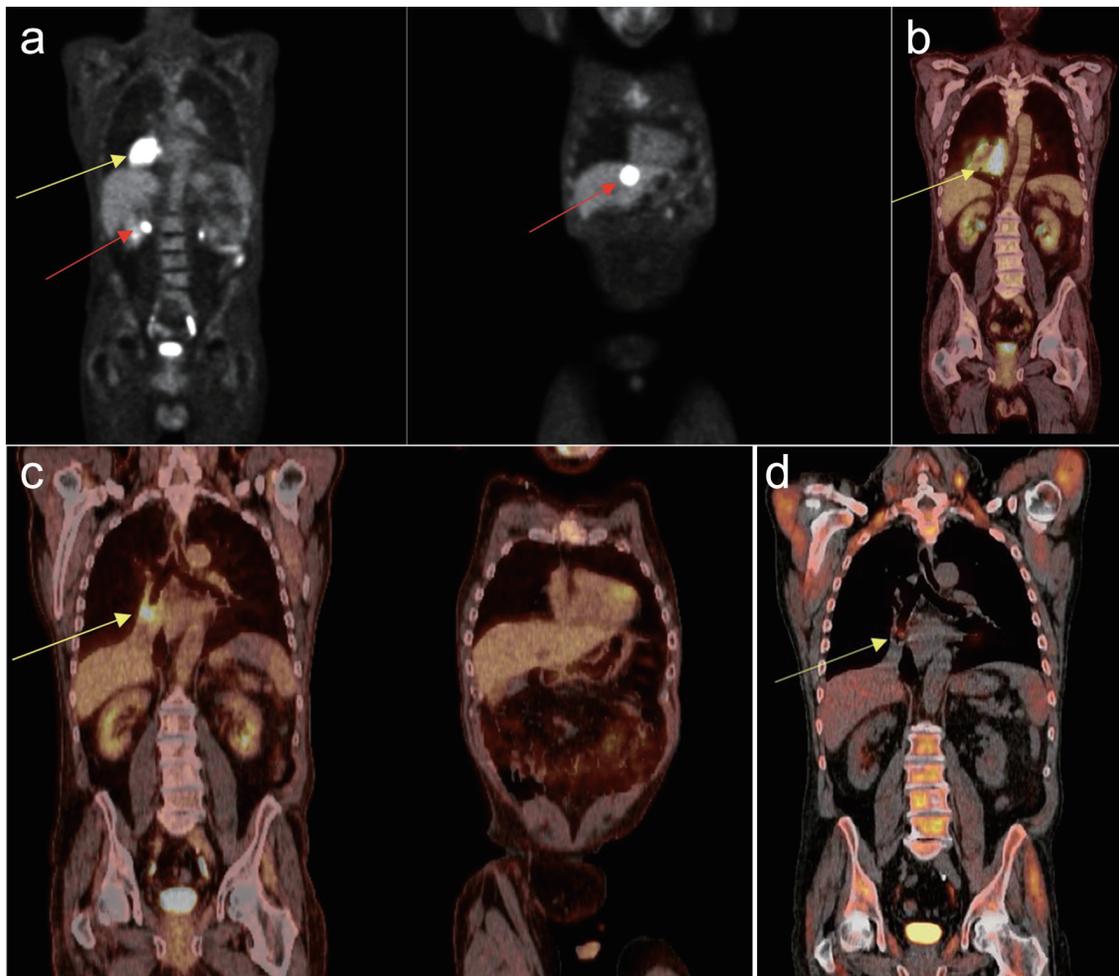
Positron emission tomography/computed tomography (PET/CT) over patient's disease progression and treatment. (a) After rituximab: showing large mass in right lower lobe of the lung (yellow arrow) and lesions in segment 2 and 7 of the liver (red arrows). (b) After rituximab, cyclophosphamide, etoposide, vincristine, prednisone (R-CEOP) showing increase in size of the right lower lobe lesion (yellow arrow) now with central necrosis. Left lobe lesion in the liver resolved, but right lobe lesion remains. (c) After chimeric antigen receptor (CAR)-T cell therapy showing resolution of right lower lobe lesion with reduction in size of parahilar lesion (yellow arrow). Resolution of the liver lesions also noted. (d) Further reduction of the parahilar lesion 5 months post-CAR-T cell therapy (yellow arrow).
